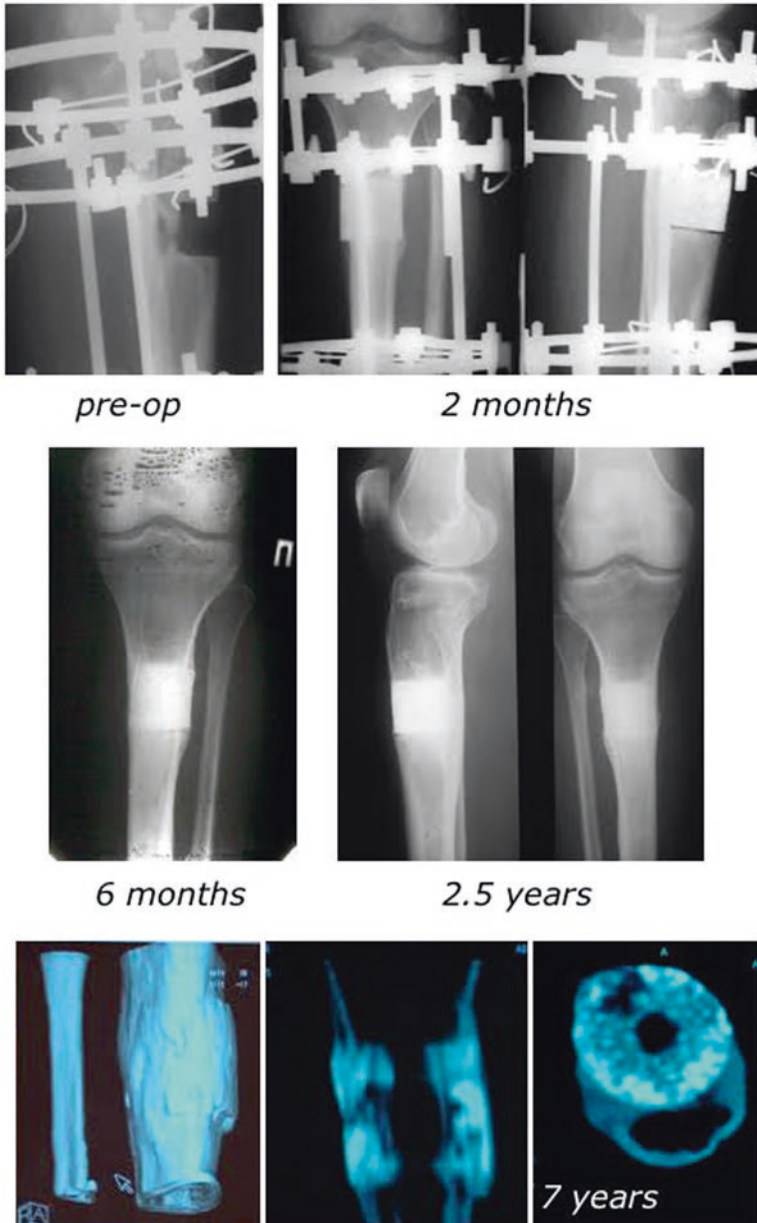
X-rays and CT scan at different follow-up times of the first patient whose long bone defect in the proximal tibia was treated by the implantation of a porous ceramic scaffold seeded with in vitro expanded autologous BMSC. On the preoperative radiograph, a 4-cm long gap of the bone is shown. At 6 months, a good integration between the implant and the tibia was already observed. CT-scan analysis at 7 years showed a complete healing of the gap, but the non-reabsorbable HA ceramic scaffold was still present
